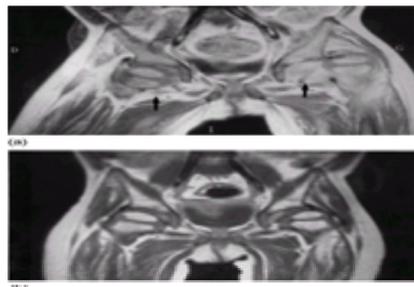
Juvenile chronic arthritis. Systemic onset disease with hip involvement in a 3-year-old girl. Enhanced T_1 -weighted MR image: (a) Prior to intra-articular injection of steroid: bilateral, active enhancing pannus is seen (arrow) with left hip dislocation. (b) After intra-articular injection of steroid: bilateral decrease in volume and enhancement of pannus with normal femoral head containment.
